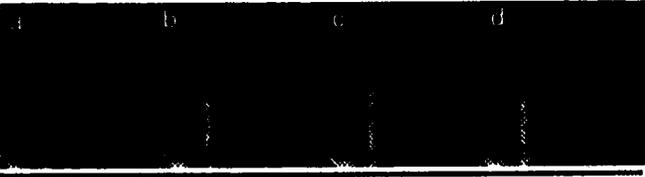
A feature space sequence generated from MR and CT images registered (a) and rotated by 2.5° (b), 7.5° (c) and 20° (d) about a cranio-caudal axis.
